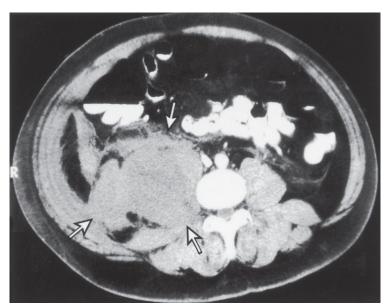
Computed tomography scan of a retroperitoneal hematoma in a patient with severe hemophilia A. Extent of the hematoma is indicated by the *arrows*. (Source: *Williams Hematology*, 9th ed, Chap. 123, Fig. 123–8.)
